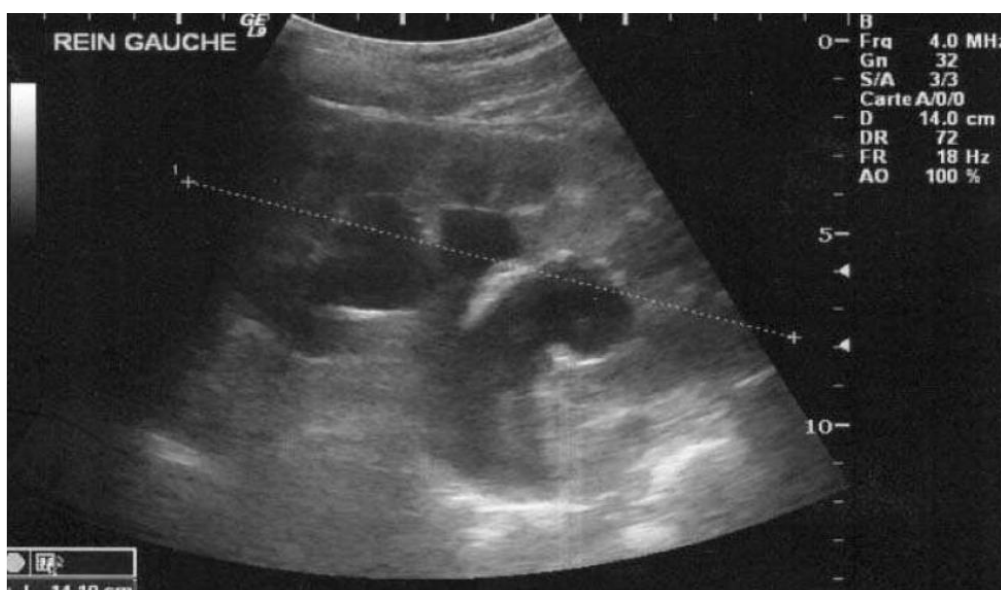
Ultrasound showing dilation of the renal collecting system
